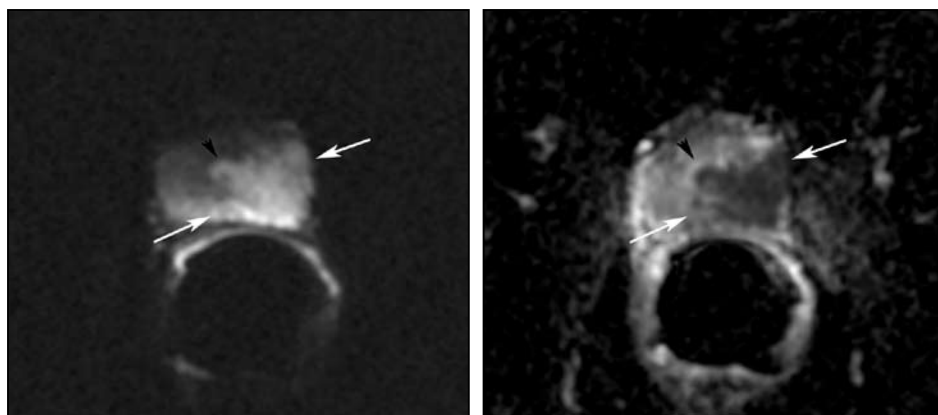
Diffusion weighted imaging of the prostate at the level of the mid-gland. a. (left) Diffusion weighted imaging with a b-value of 1000. b. (right) Apparent Diffusion Coefficient (ADC) map at the same level. Tumors, especially those of higher Gleason grade, show increased signal on DWI and correspondingly decreased values on ADC map (white arrows). Note the increased conspicuity of central gland involvement compared to T2 weighted images (black arrowhead).
